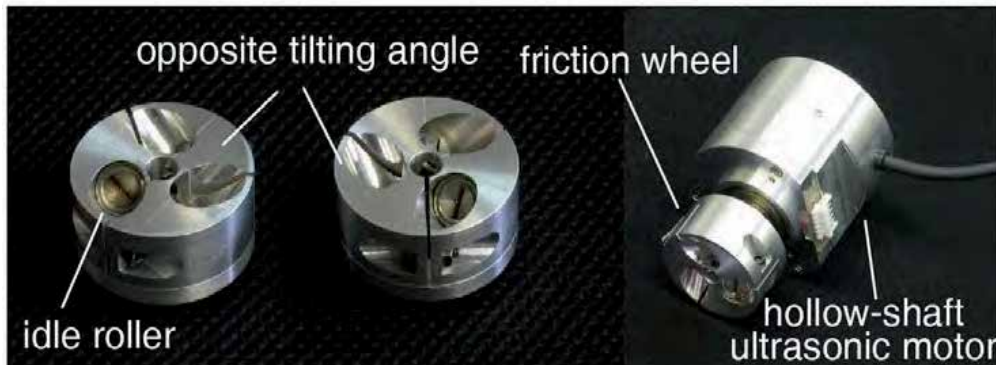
A couple of friction wheel; Each friction wheel has three tilted driving rollers with opposite tilting angle (left). Hollow-shaft ultrasonic motor is adopted for actuation (right)
